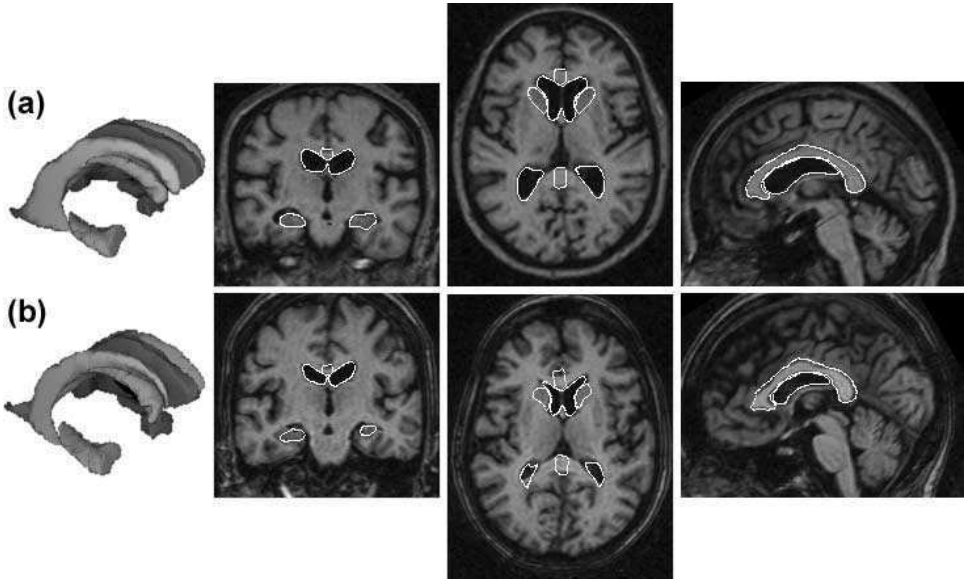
(a) Reference MRI with manually delineated structures and (b) reference MRI registered to an input MRI and initialized structures.
